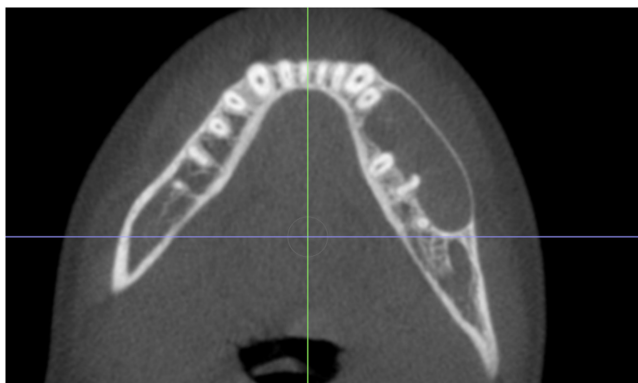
CBCT image scans showing the size and extent of the OKC lesion in three dimensions.
